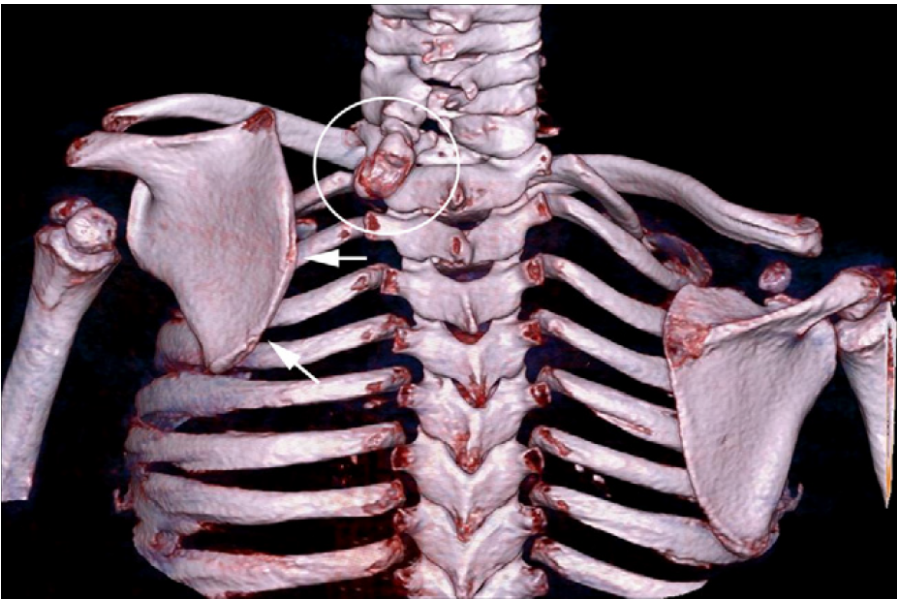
CT scan (posterior view in 3D VRT reconstruction). The omovertebral bone is clearly visible. Note the scapular dysmorphia (arrows), the raised ipsilateral clavicle, and the cervical spina bifida occulta [5].
